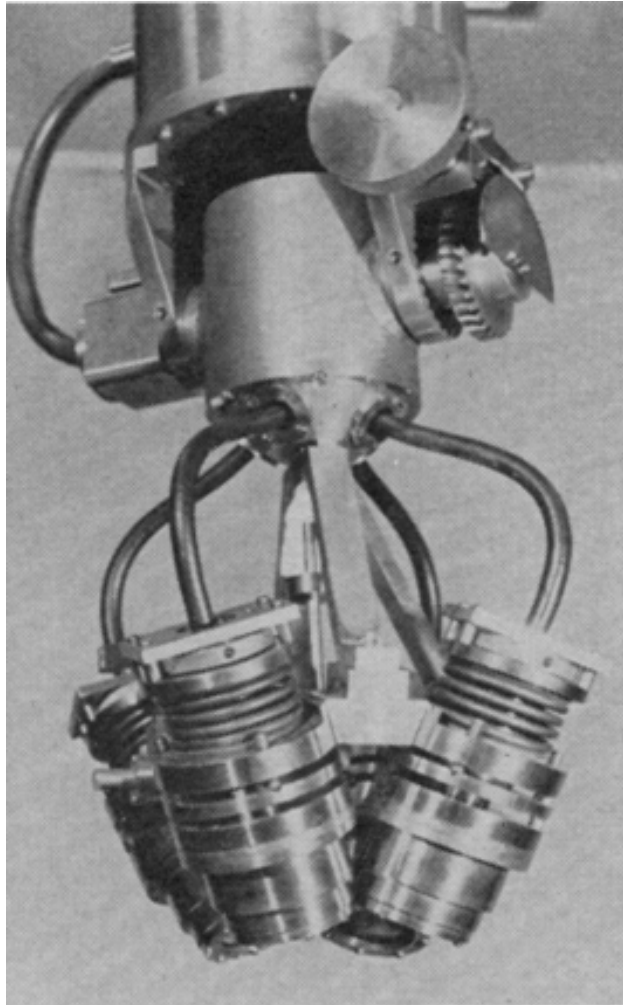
First multibeam focused ultrasound device.
